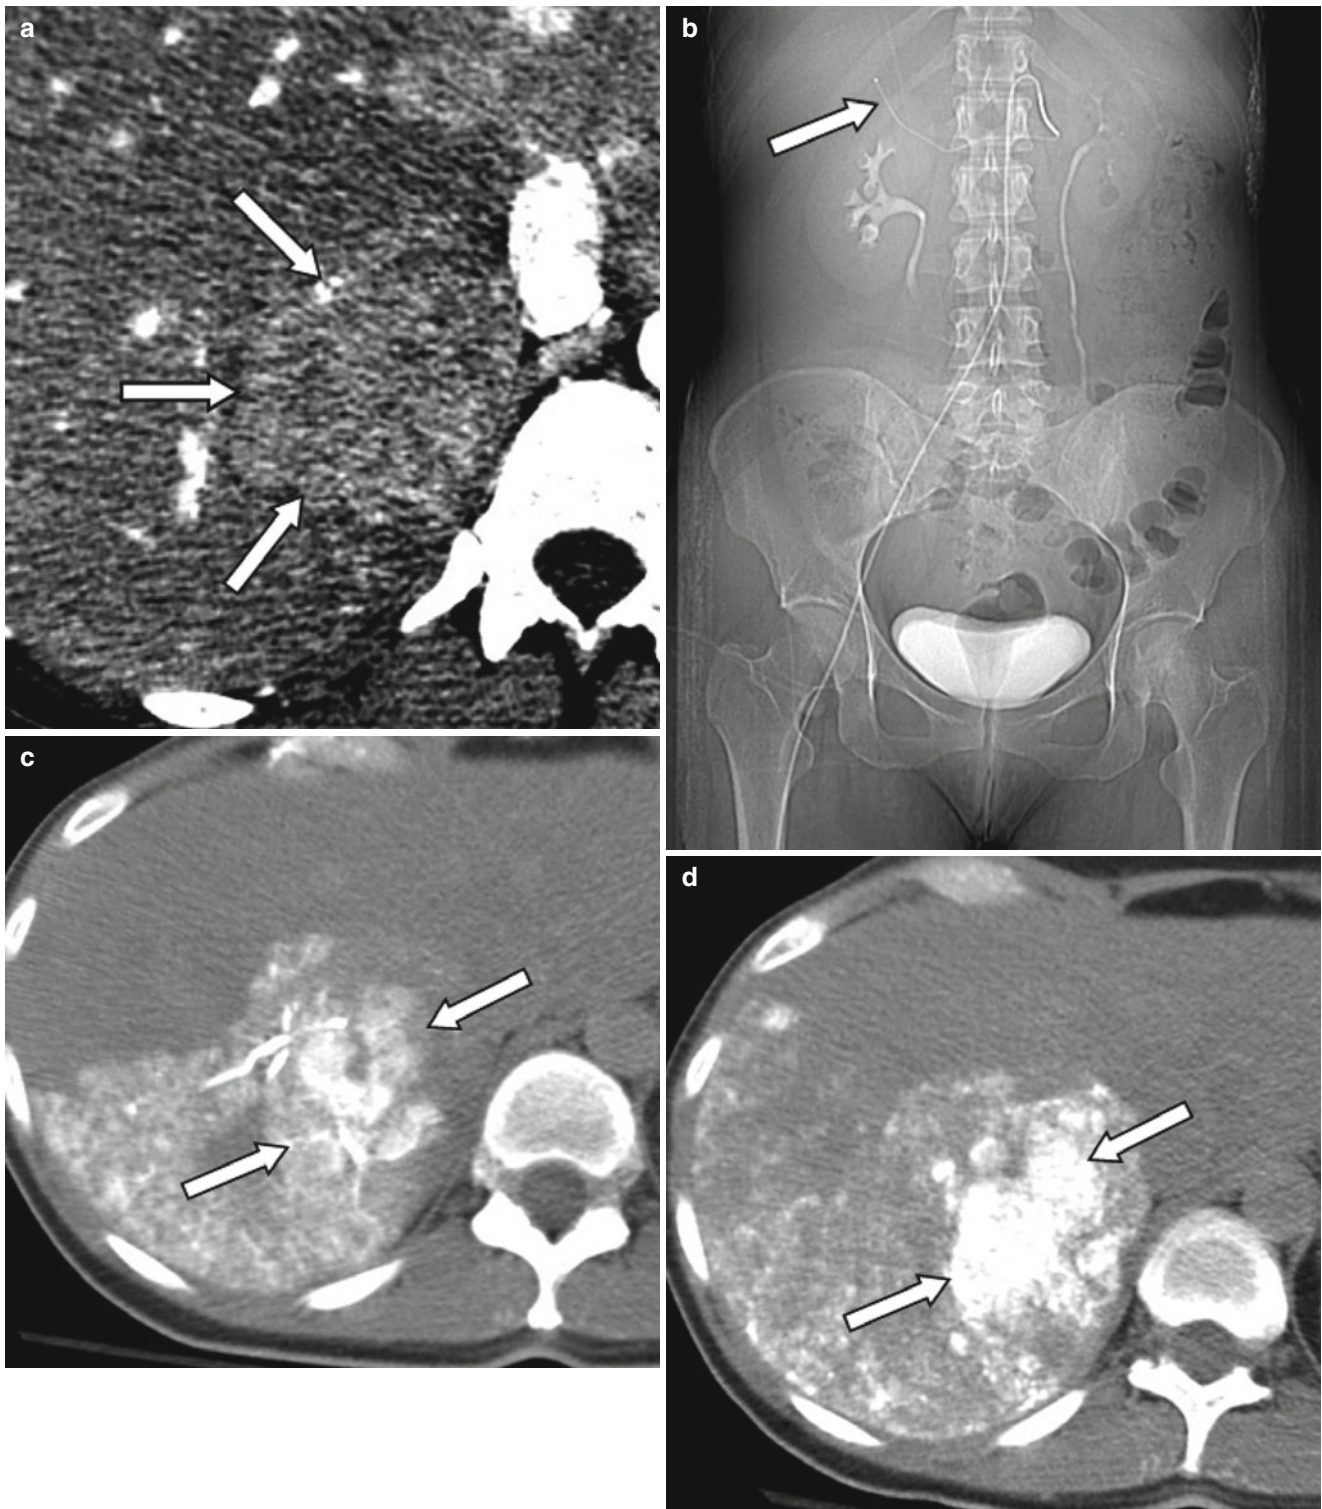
A 48-year-old female patient with ocular melanoma metastasis to liver. Pre-treatment contrast enhanced CT demonstrates a large mass in the right lobe posterior segment of the liver (*arrows*) (a). Patient subsequently received TACE treatment (b–d) with superselective catheterization of the posterior branch of the right hepatic artery as seen on the scout CT image (*arrow*) (b). In order to assess ethiodized oil retention within the tumor, patient was evaluated with CT right after administration of ethiodized oil (c). Since there was insufficient treatment of tumor, additional chemoembolization material was administered, and sufficient therapy was confirmed with a second CT examination performed 2 h after the procedure (d)
